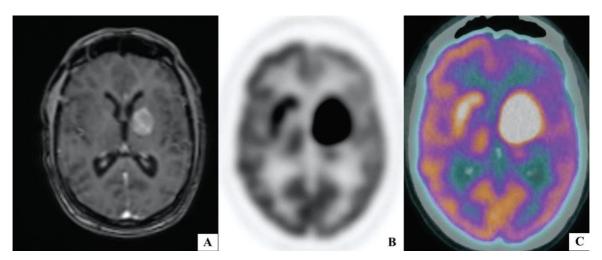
(A) Gadolinium-enhanced T1-weighted MR axial and ¹⁸F FDG PET and fused ¹⁸F FDG PET/CT axial (B, C) showed enhancing mass in the left thalamus, internal capsule and lentiform nucleus with hypometabolism of ipsilateral parietotemporal region.
